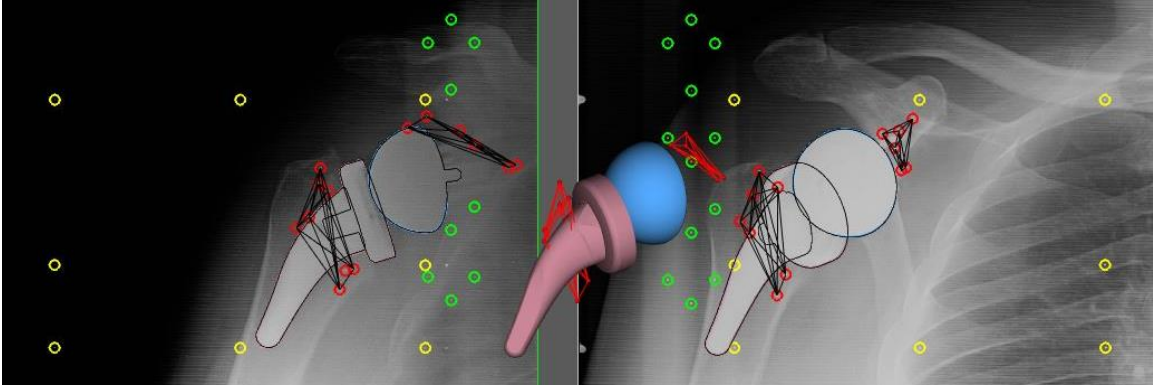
Calibration cage fiducial (yellow) and control (green) beads determine the global reference frame. Glenosphere (blue) and humeral stem and tray (pink) contours are detected on x-rays taken 40° to one another, their surface models aligned within the global frame to match. Tantalum beads within the bone are detected (red circles), defining the reference rigid body against which implant migration is measured over time.
